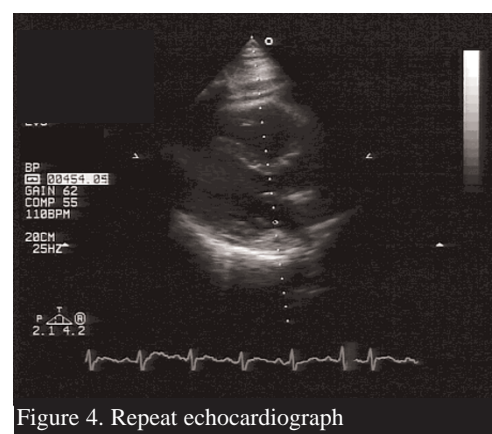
Repeat echocardiograph
